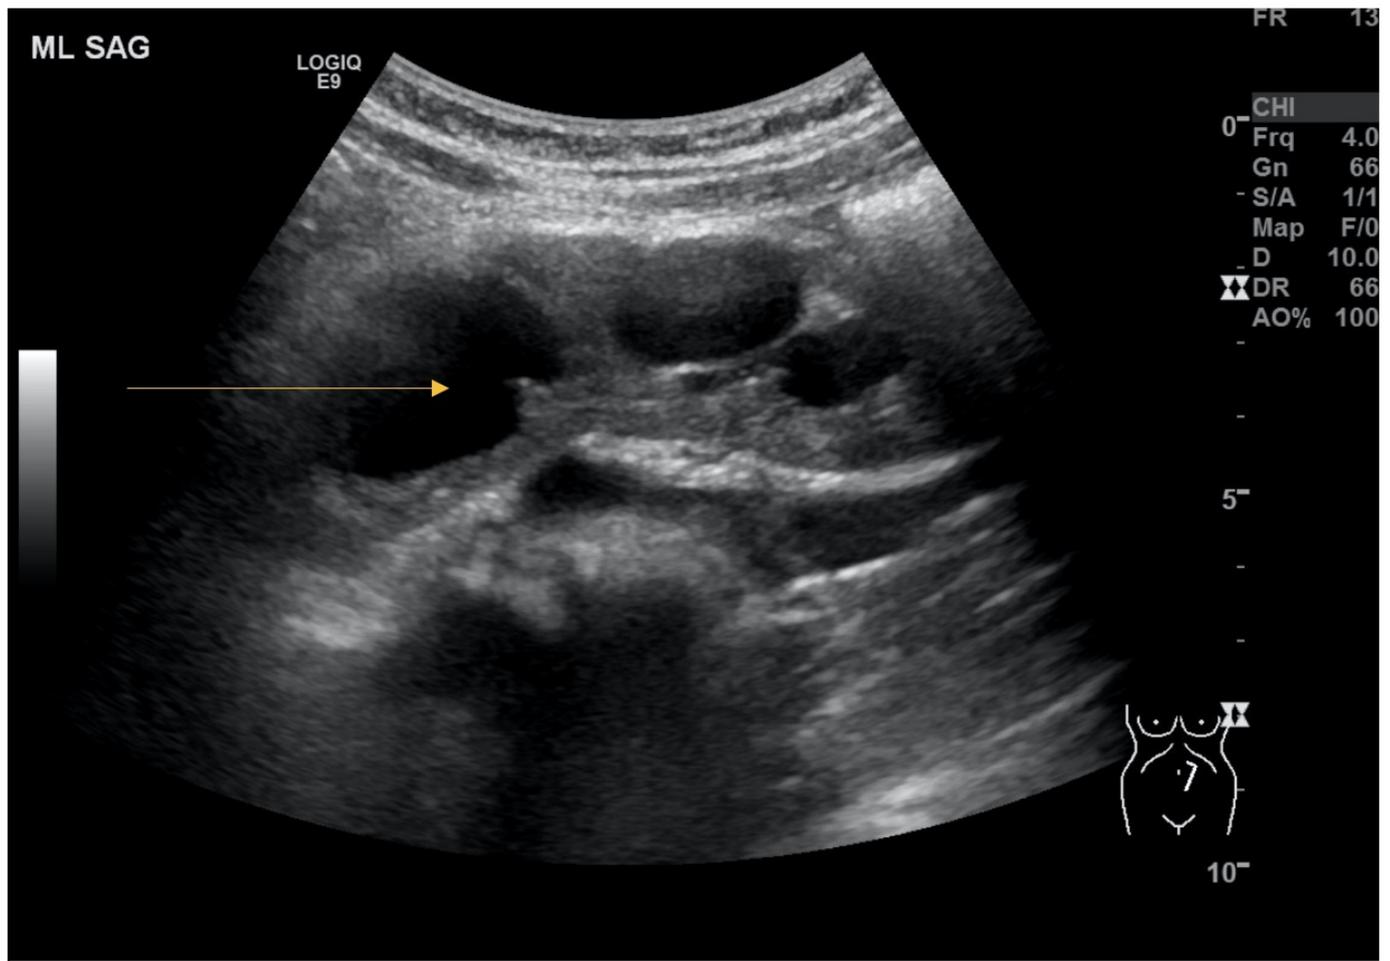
Follow up ultrasound shows midline ectopic kidney with pelvicalyectasis (yellow arrow).
